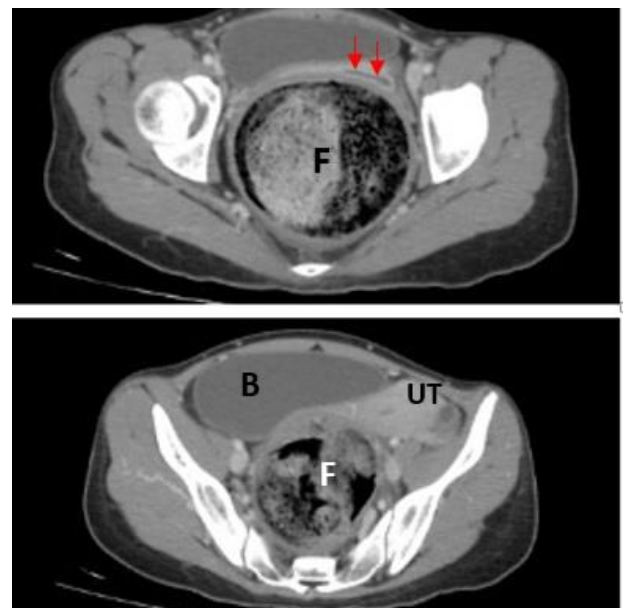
Axial view CT scan pelvis showing compressed vagina (arrow), bladder (B), uterus (UT) and faecaloma (F).
